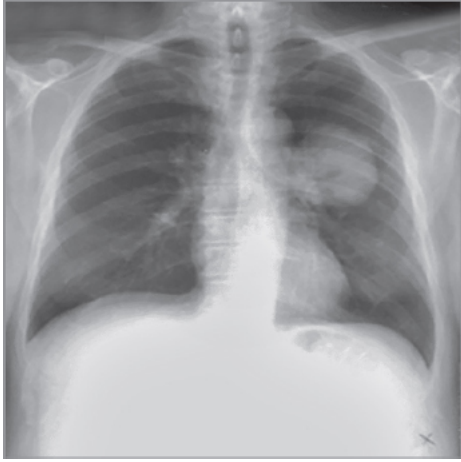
Chest X-ray PA view showing rounded homogeneous lesion in the right mid zone—solitary pulmonary nodule.
